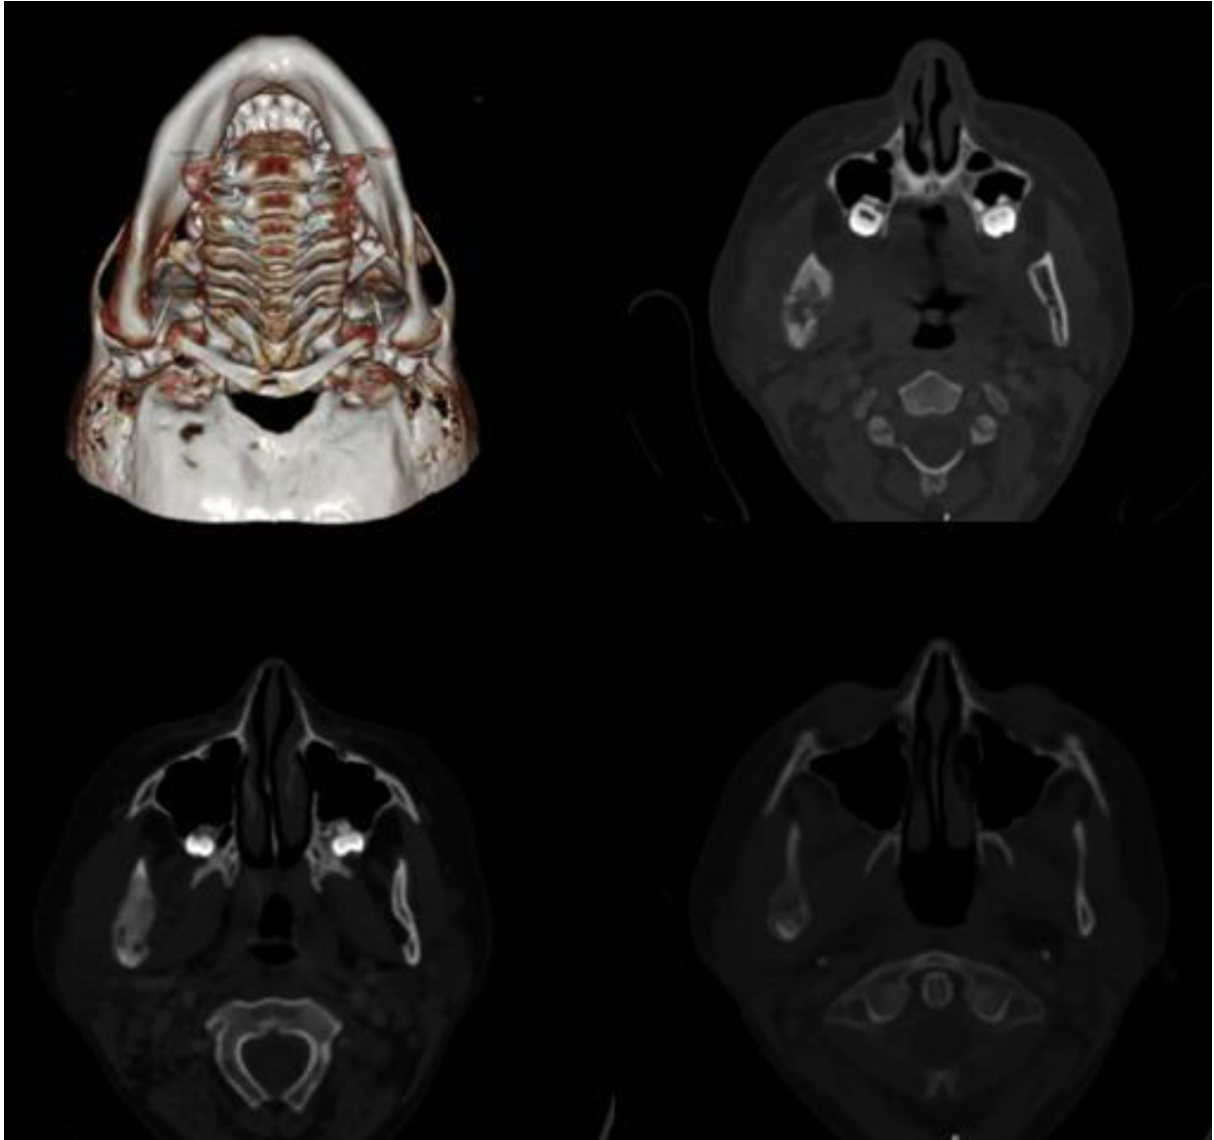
3D reconstruction shows enlargement of the right angle, ramus, and condylar process of the mandible. Axial cranial CT sections show mixed lesions described as “ground-glass”, “cystic”, “pagetoid” or “lytic” and involving the right ramus of the mandible together with the condyle and coronoid process
